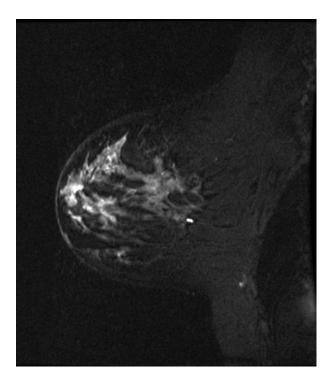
CAD assistance with interpretation of the axial left breast MRI image
